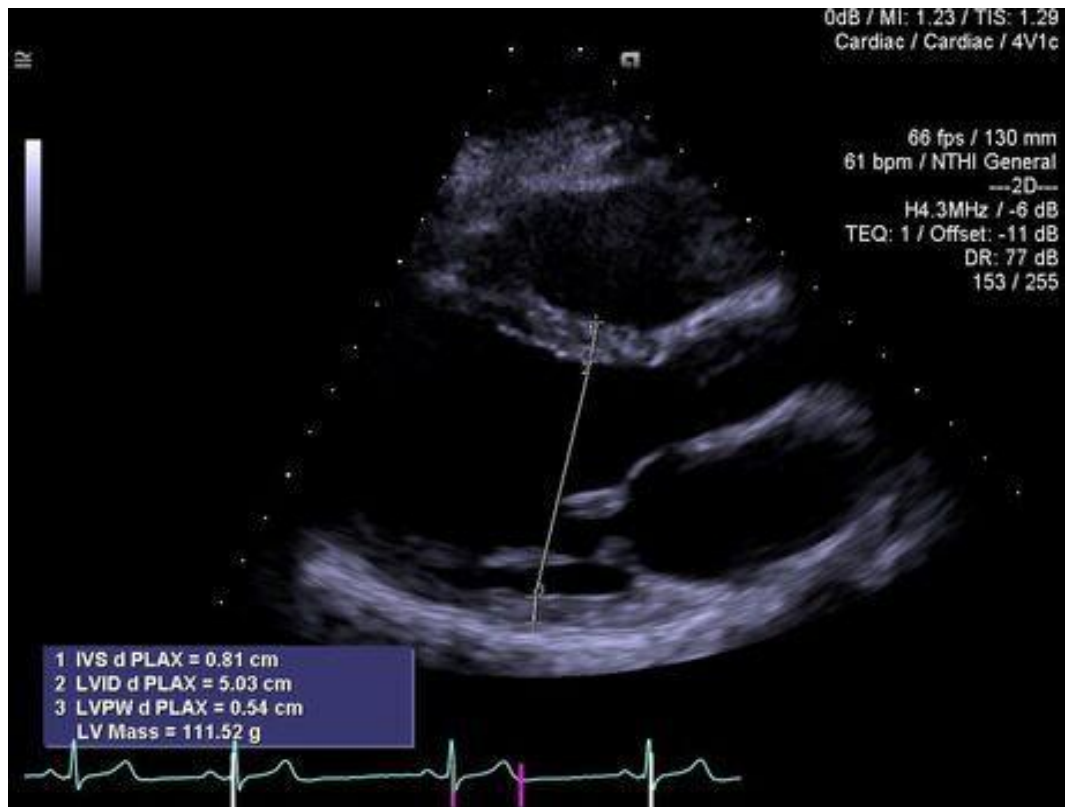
M-Mode ultrasound of the left ventricle showing measurement of dimensions for the calculation of LVM. *Courtesy of Siemens Healthineers.*
